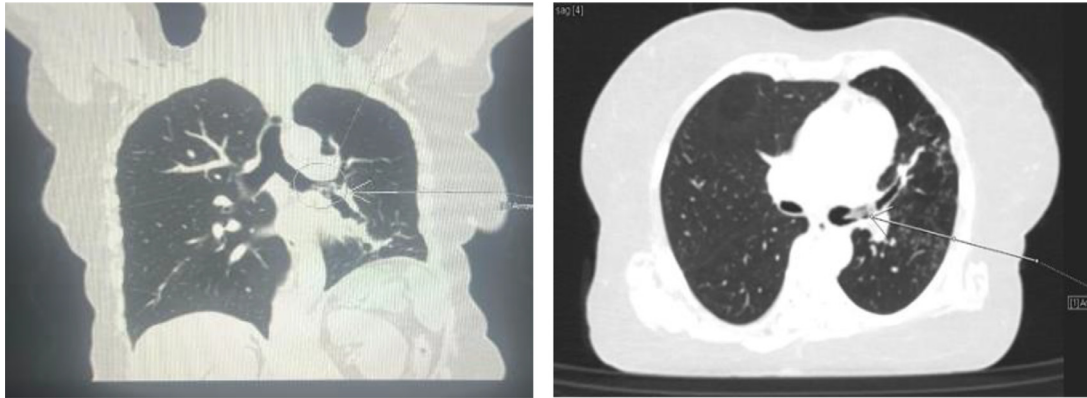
Review of the first CT scan images showed a high-density foreign body (approximately – 250 HU density) is seen in the left main bronchus, approximately about 2.86 cm distal to carina impacted at the bifurcation into the 2 lobar bronchi, the left upper and lower lobar bronchi. (black arrow). Furthermore, there was a hypodense opacity in the left lower lobe that was best seen in coronal views with classic finger in glove appearance which represents mucous filling dilated bronchi (20–28 HU density) consistent with mucoid impaction.
